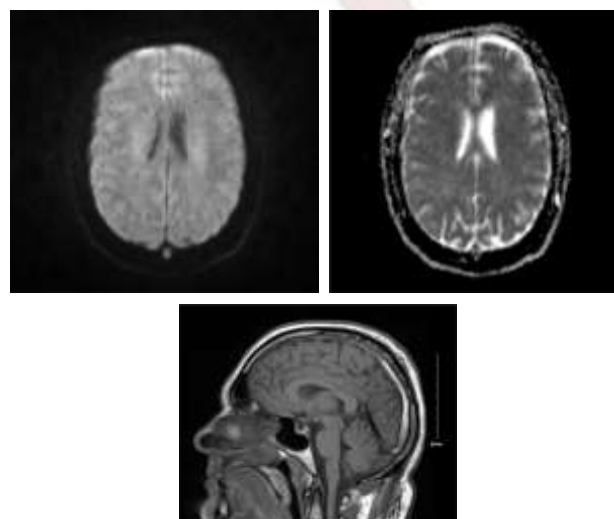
(A) DWIs and ADC map showed normal left cerebral hemisphere without acute infarction. Note the restricted dot in the SSS. (B) Sagittal T1WIs depicted hyperactive intense SSS related to the previously seen thrombosis on CT and CTA.
